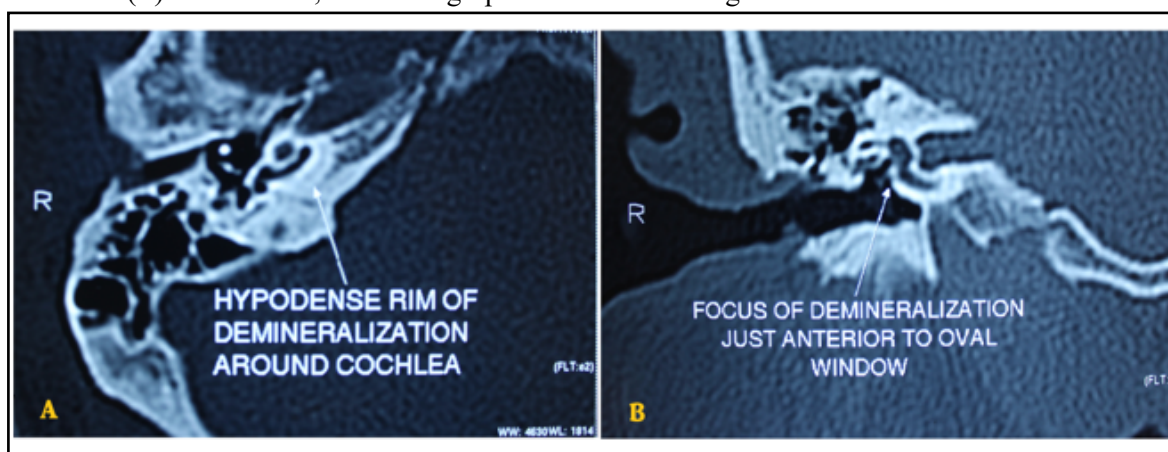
Axial HRCT image of patient no 11 showing circumferential rim of hypolucency in pericochlear region on (R) side (A). Coronal HRCT image of patient no 11 showing focus of demineralization just anterior to stapes footplate (B).
